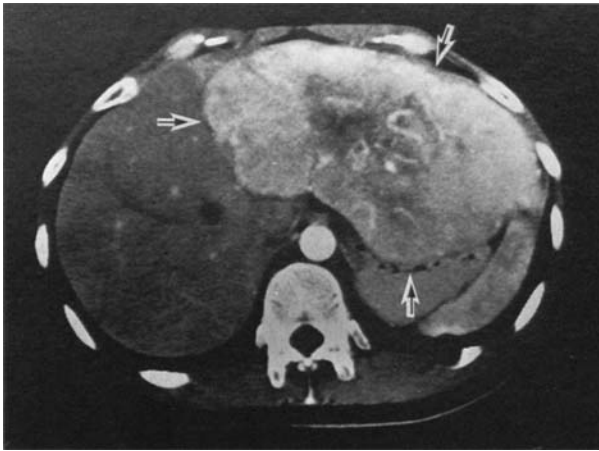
Abdominal CT scan showing a large mass in the left lobe of the liver (arrows).
